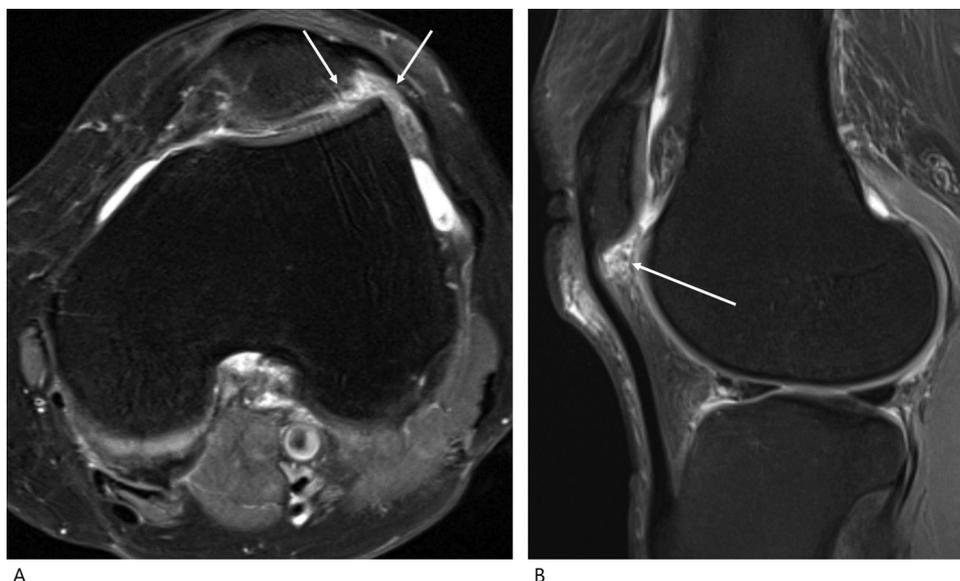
A 49-year old woman with anterior knee pain. (A) Axial and (B) sagittal proton density-weighted fat-saturated MR images showing focal ill-defined oedema-like signal intensity in the superolateral Hoffa's fat pad (dotted circles).
